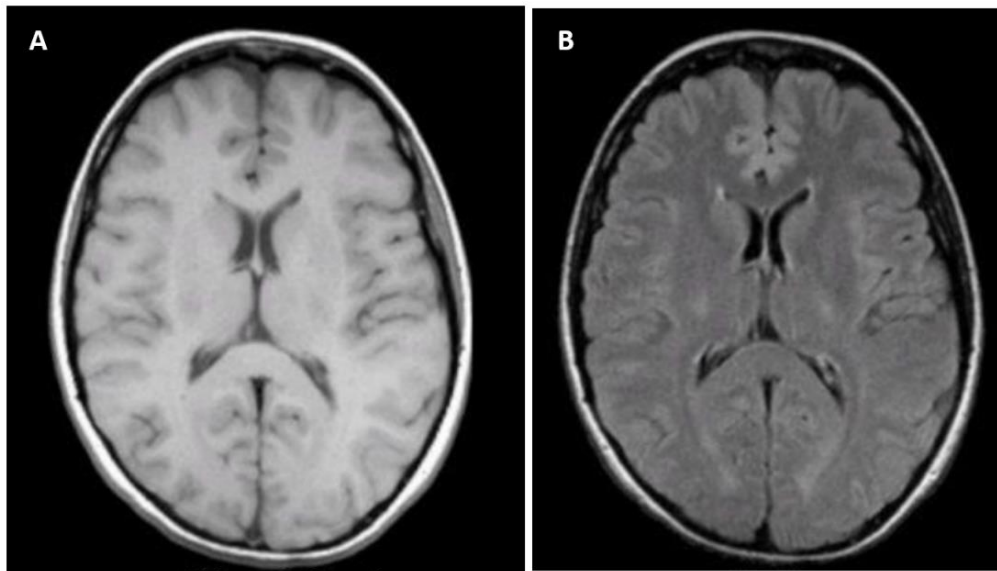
A) MRI scan of a patient with a healthy brain (T1 weighted), and B) FLAIR image of the same patient [7].
